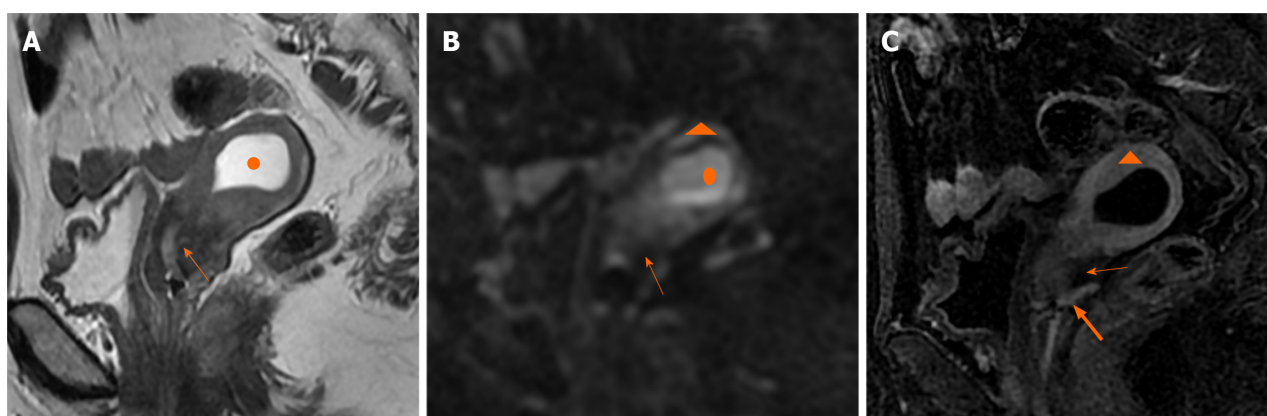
Endometrial carcinoma involving the cervical stroma in Case 3. A: On the T2-weighted imaging image, the endometrium cannot be seen, with fluid accumulation in the cavity (circle). The cervix stroma is depicted as low signal (arrow); B: On the diffusion weighted imaging (DWI) image, the fluid accumulation within the cavity is blood, and the DWI displays a slightly elevated signal (circle). Additionally, the myometrium exhibits a marginally high signal (triangle), while the cervix interstitial region maintains a low signal (arrow); C: On the enhanced image, the endometrium cannot be seen, while the muscle layer shows marked prominent enhancement (triangle). The cervix stroma shows hypo-enhancement (narrow arrow), but the mucosa is significantly enhanced (bold arrow).
